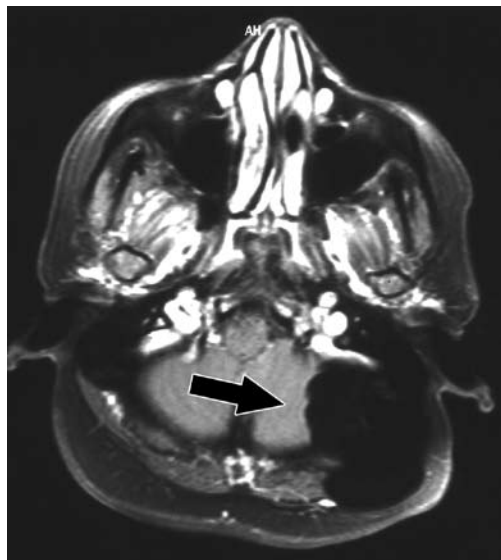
A contrast-enhanced axial cranial MRI shows a non-enhancing mass spreading into and out of the cranium.
